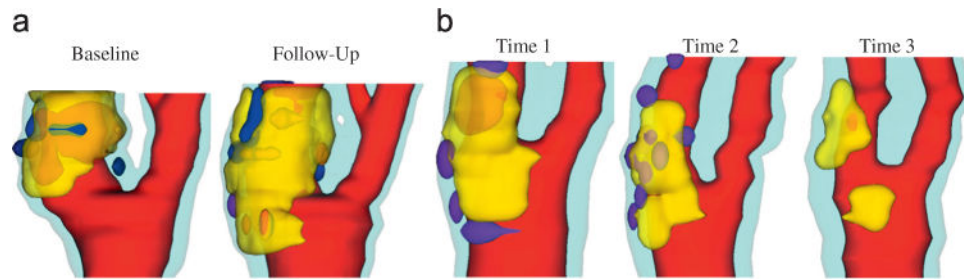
3D human carotid plaque samples re-constructed from in vivo MR images showing progression and regression. Time interval: 18 months. Red: lumen; yellow: lipid; dark blue: calcification; light blue: outer wall. (a) Plaque showing progression and (b) plaque showing regression. (For interpretation of the references to color in this figure legend, the reader is referred to the web version of this article.)
